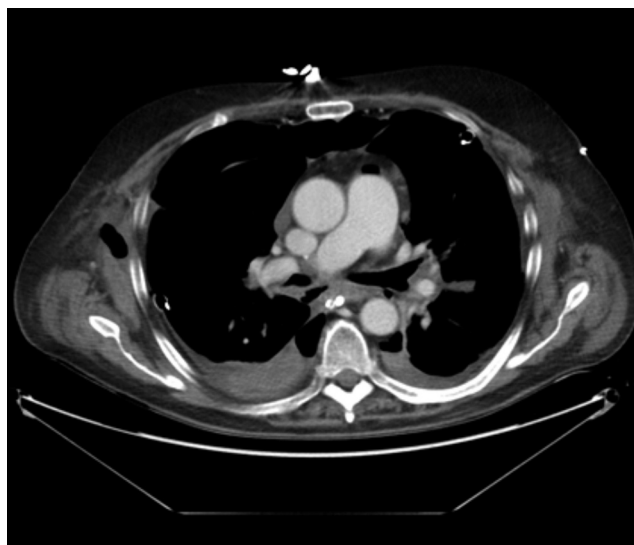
CT image showing a bronchial dehiscence in posterior aspect of a left bronchial suture after double-lung transplantation.
